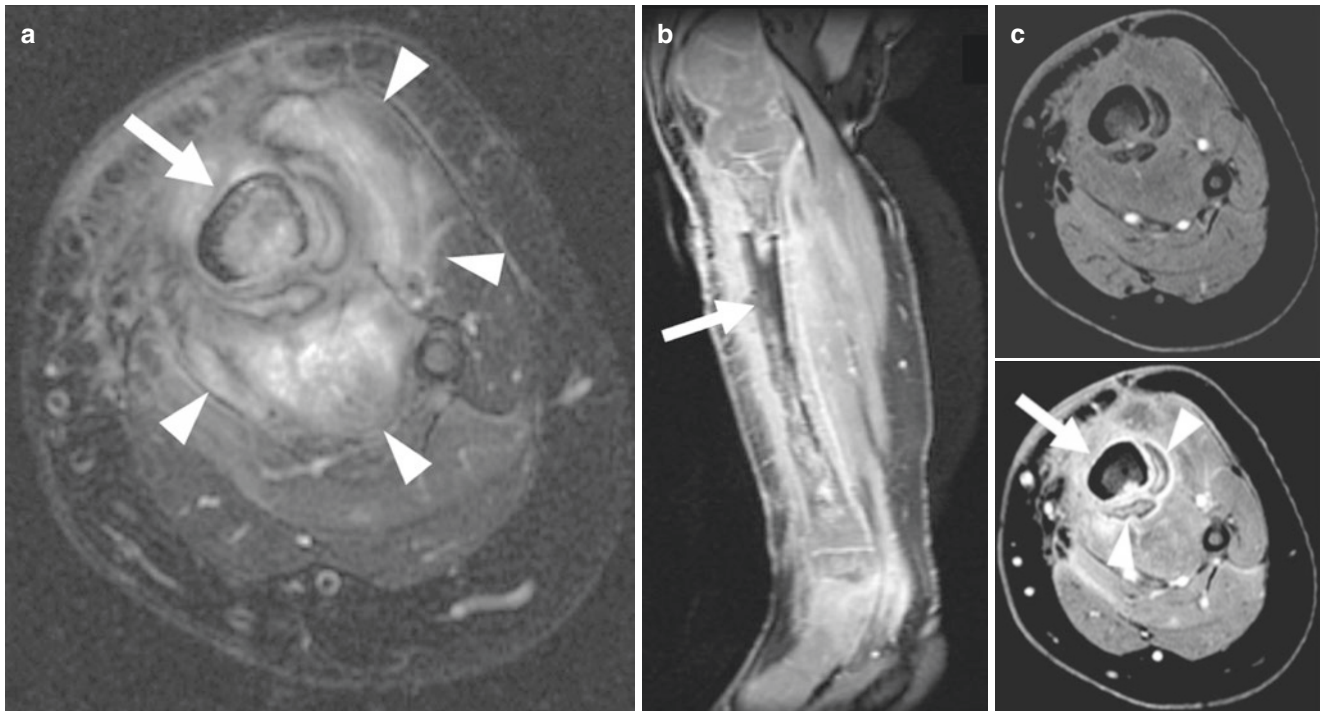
A 6-year-old boy with chronic leg pain and fevers. Biopsy-proven osteomyelitis. Axial T2-weighted fat-suppressed MR image (a) of the lower leg demonstrates abnormal signal in the tibia (arrow) representing osteomyelitis. Note surrounding phlegmonous tissue (arrowheads). Sagittal T1-weighted fat-suppressed post-contrast image (b)
